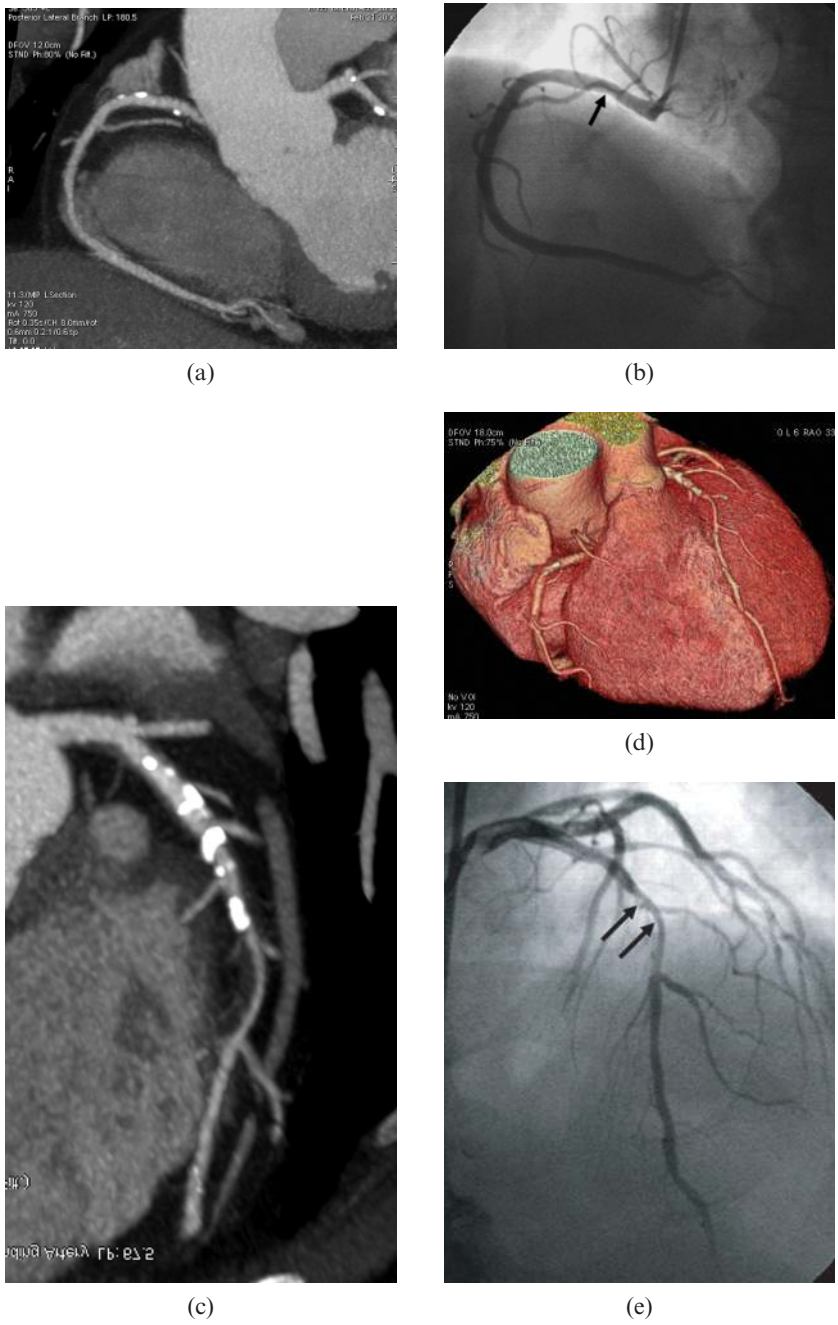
Coronary CT angiography of calcified plaques beyond lumino-graphy. CT maximum-intensity projection shows focally calcified plaques in the proximal segment of the right coronary artery (a). Corresponding coronary angiography shows mild coronary lumen stenosis [arrow in (b)]. Extensive calcified plaques are noticed in the proximal and middle segments of left anterior descending (LAD) on curved multiplanar reformat (c) and volume rendering images (d). A significant stenosis of LAD is confirmed on coronary angiography [arrows in (e)].
